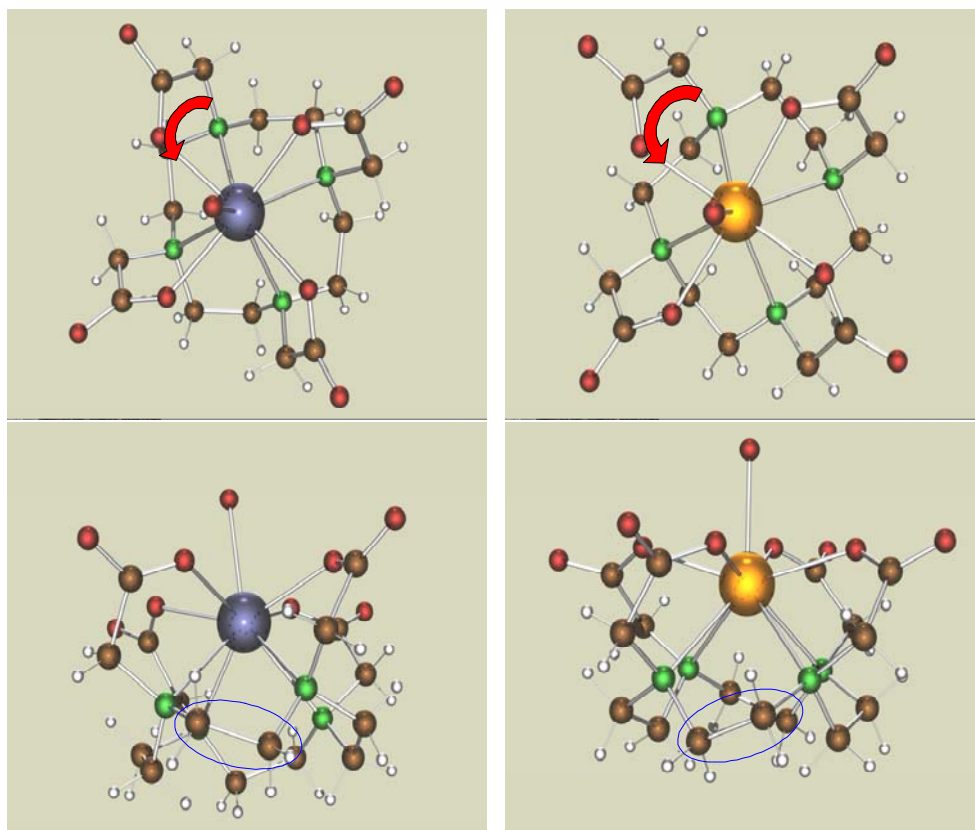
X-ray structure of $\text{Ce}(\text{DOTA})(\text{H}_2\text{O})^-$ (TSA, left) and $\text{Nd}(\text{DOTA})(\text{H}_2\text{O})^-$ (SA, right)
